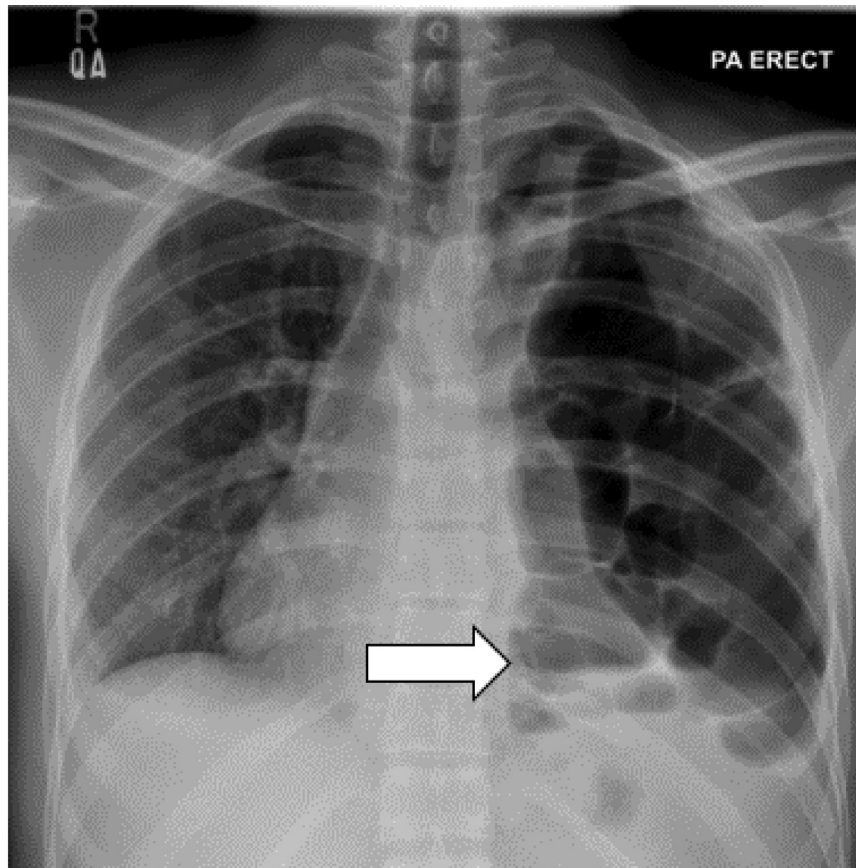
Chest radiograph indicated a left-sided hydropneumothorax. Gas-fluid levels (arrow) are seen in the left hemithorax.
